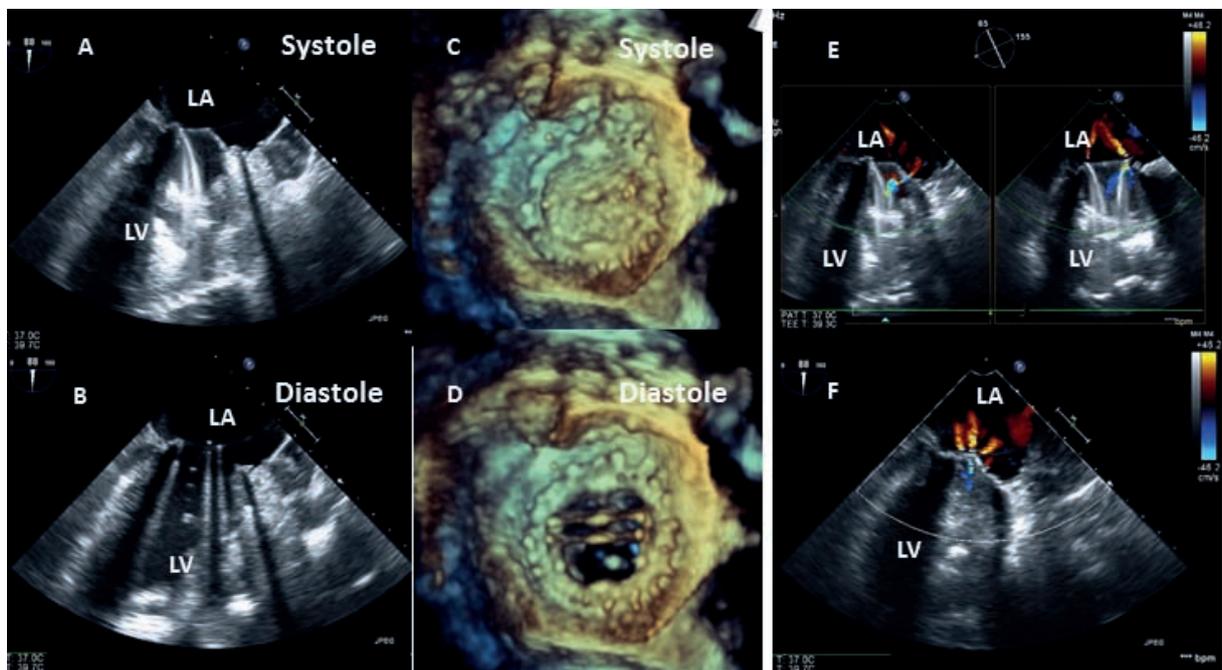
A normal functioning St. Jude (St. Jude Medical, Secaucus, NJ) mechanical mitral prosthesis. Transesophageal echocardiographic images of a normal functioning St. Jude mechanical mitral valve prosthesis demonstrating normal opening during diastole and closing during systole, seen both on two-dimensional (A & B) and three-dimensional (C & D) imaging. (E & F) Using color Doppler normal physiologic regurgitation jets are seen. Depending on the angle obtained, either two jets (E) or three jets (F) can be seen. Note the extensive shadowing caused by the mechanical valve on the two-dimensional images. LA, left atrium; LV, left ventricle.
